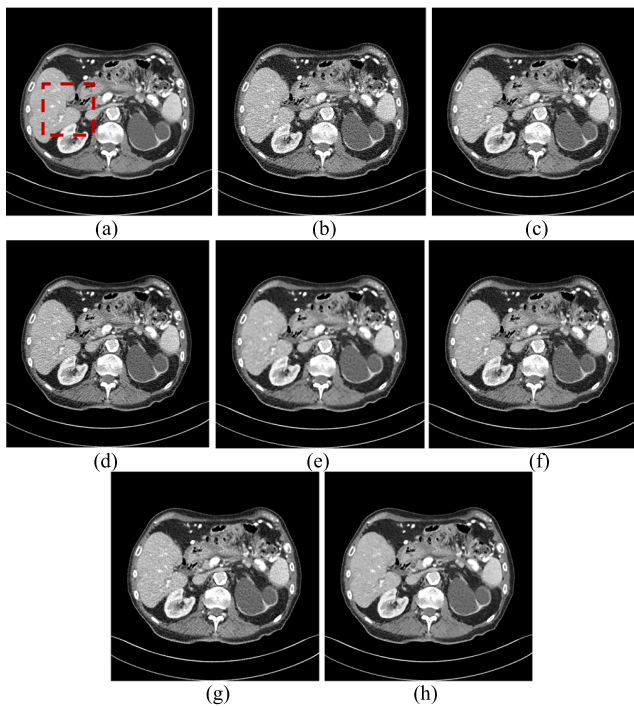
Results of another abdominal CT scan from the testing set using different methods. (a)-(h) correspond to the labels in Fig. 3.
